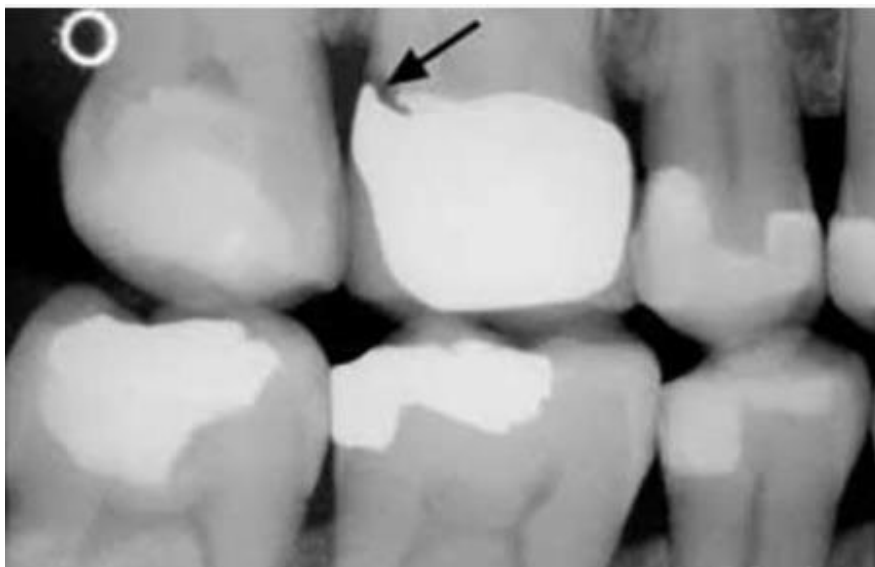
Recurrent decay seen by x-ray. The black arrow indicates dark area of decay below filling (42).
